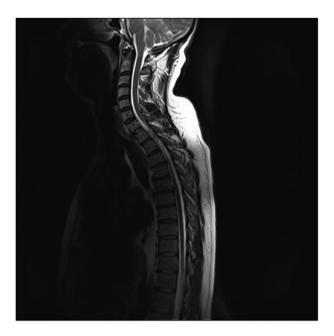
Magnetic resonance image of the cervicothoracic spine showing spinal epidural hematoma extending from C7 to T3
